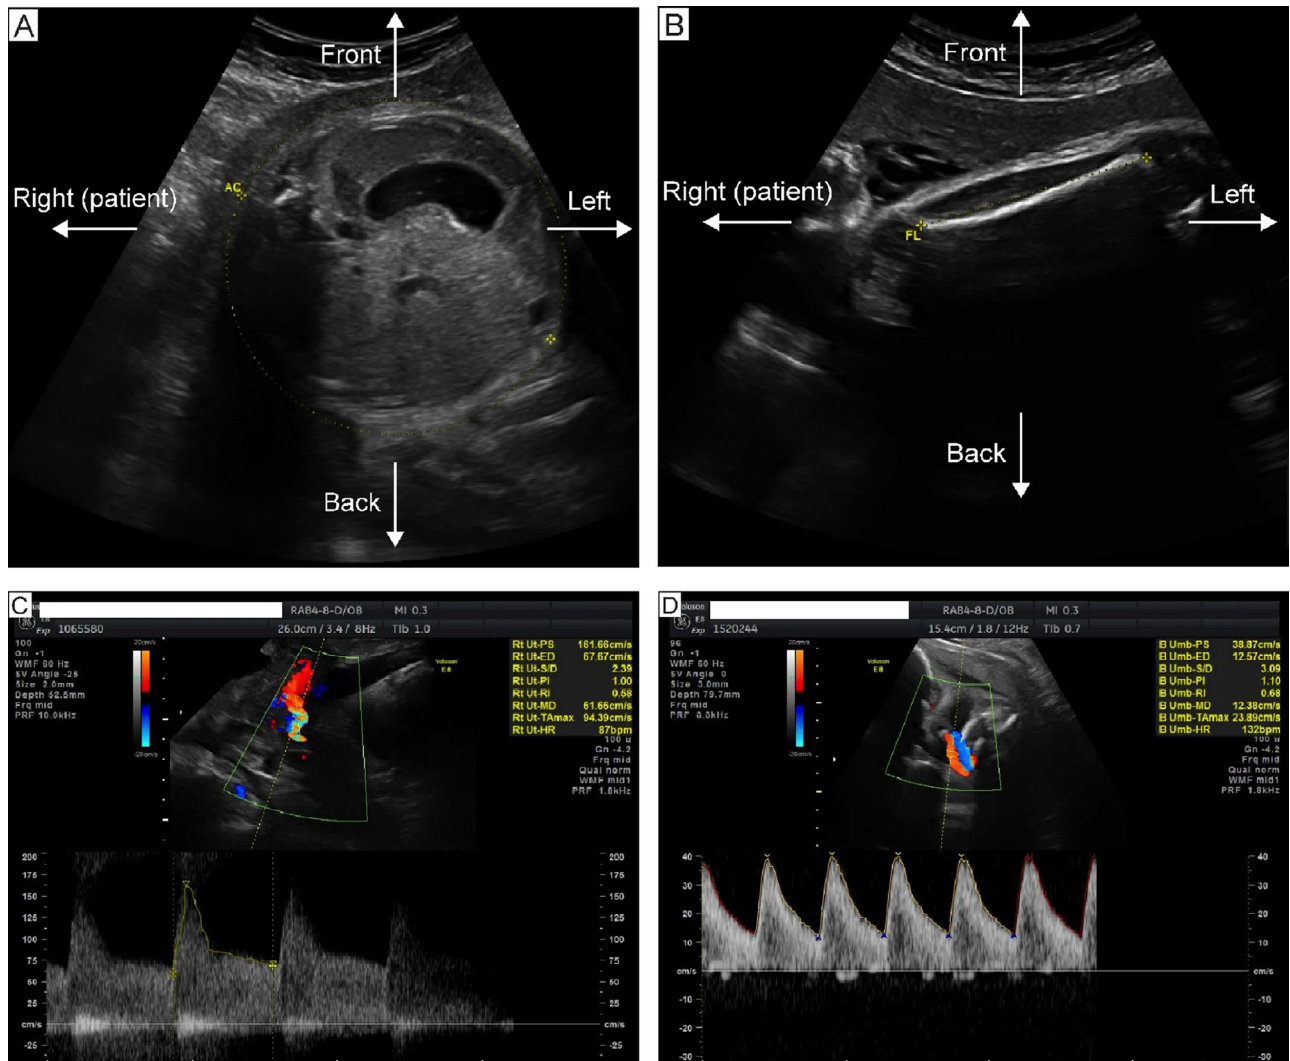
Fetal-maternal ultrasound assessment of study case at admission. (A, B) Fetal growth. (C) Uterine artery Doppler. (D) Umbilical artery Doppler. AC, abdominal circumference, FL, femur length.
